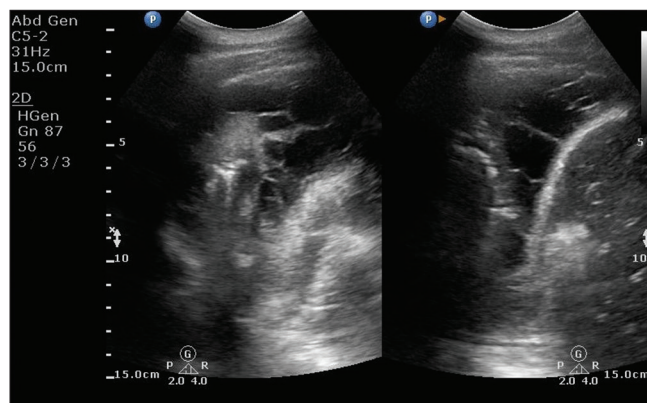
An ultrasonography showing loculated effusions
